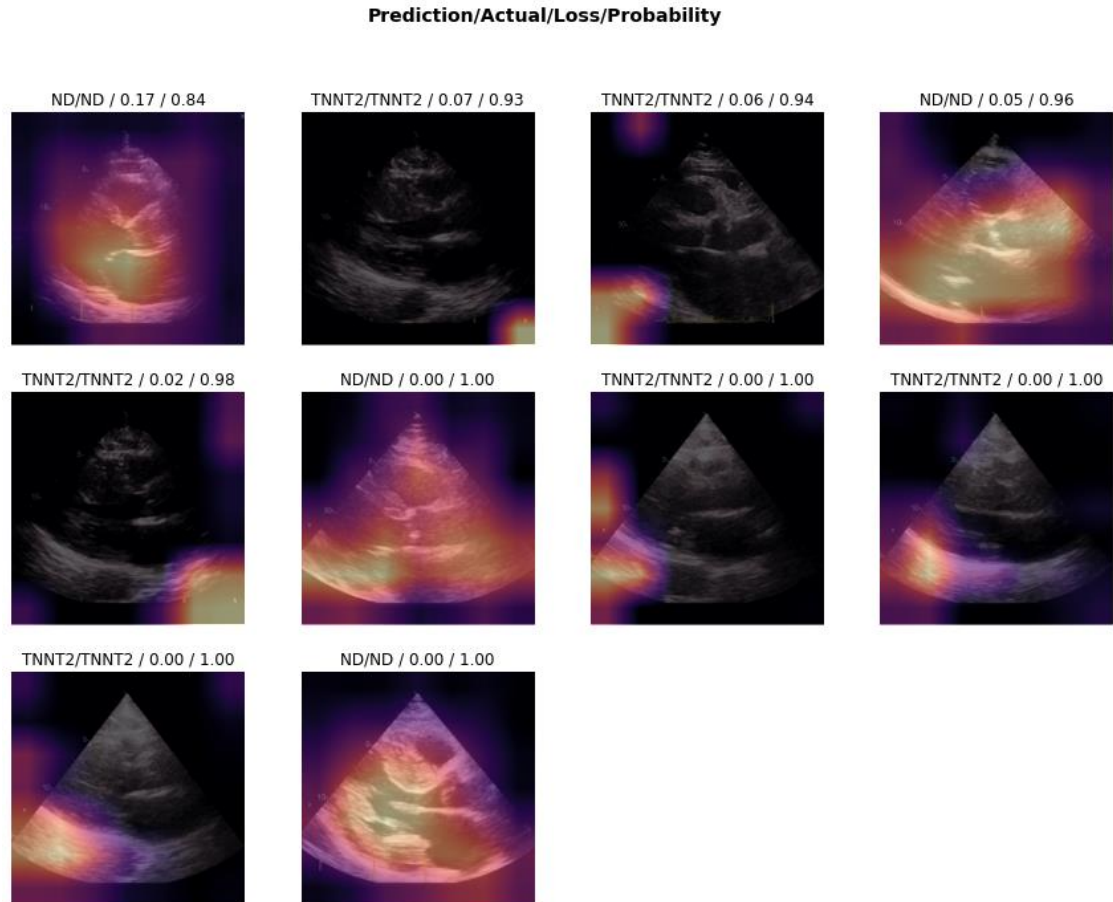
Discriminative areas for classification of a given image (*TNNT2* vs. ND), parasternal long axis view during ventricular diastole
